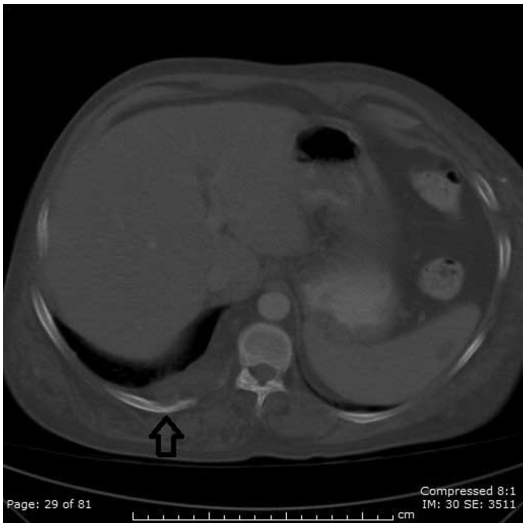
Proteus Syndrome in a 26-year-old male. Axial CT. Note bony erosions in the 10th rib adjacent to soft-tissue mass under the right crus (black open arrow).
